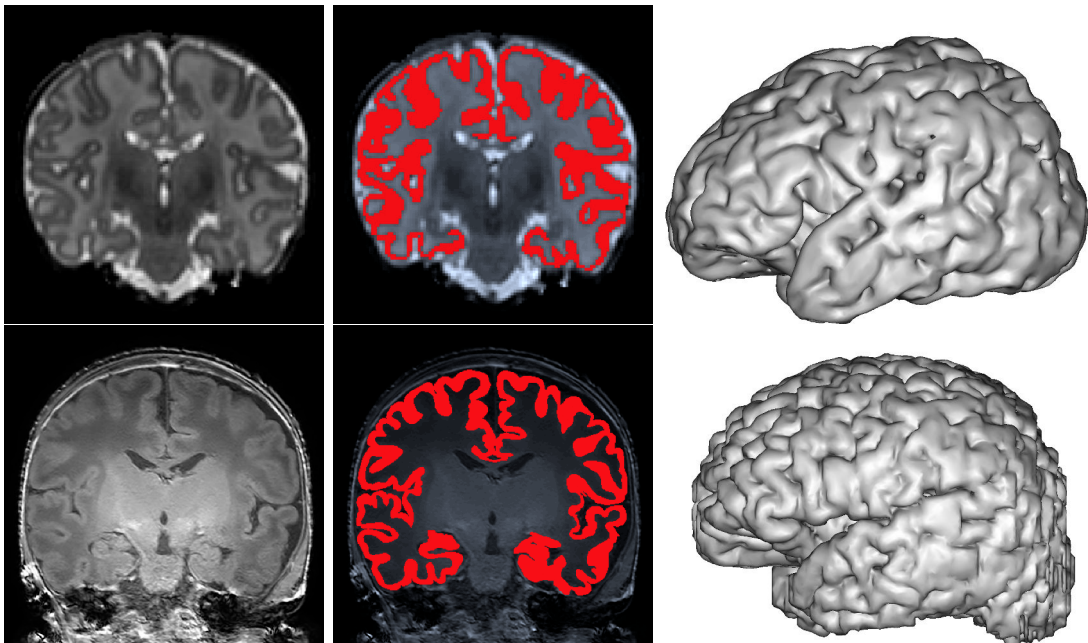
Two examples of cortex segmentation from two different datasets: on top, a T2w image from ALBERT dataset and on bottom, a T1w image from MAIA dataset. From left to right: MR image, a manual segmentation of the cortex overlapping MR image and a mesh generation obtained from BrainVISA software<sup>1</sup>.
